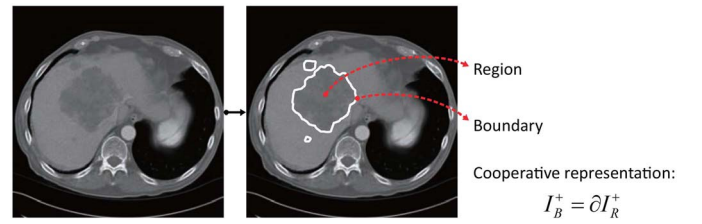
Collaborative representation of a CT image with liver tumor. The image domain is decomposed into foreground region  $I_R^+$  and background region  $I_B^-$ . We also distinguish boundaries  $I_B^+$  from the rest of image  $I_B^-$ . We strictly constrain that  $I_B^+ = \partial I_R^+$  to couple the two terms in the collaborative representation.
